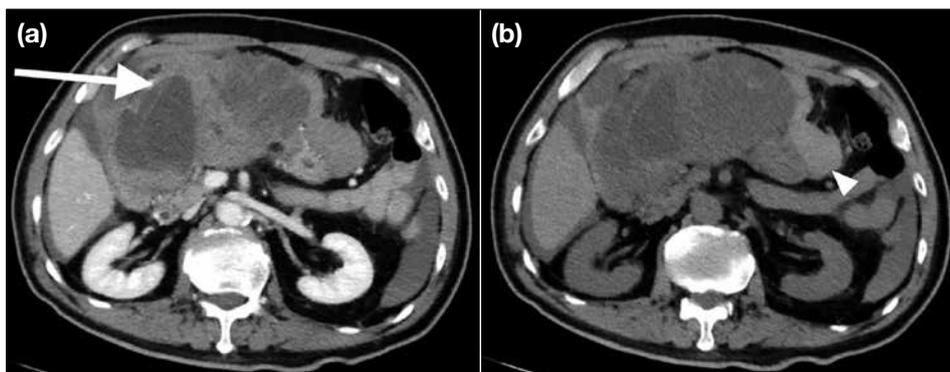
Gastric gastrointestinal stromal tumour in a 78-year-old man. (a) Contrast-enhanced computed tomography (CT) showing a large heterogeneous mass in the upper abdomen (arrow). (b) On plain CT, hyperdensities close to the tumour represent tumour bleeding (arrowhead).
